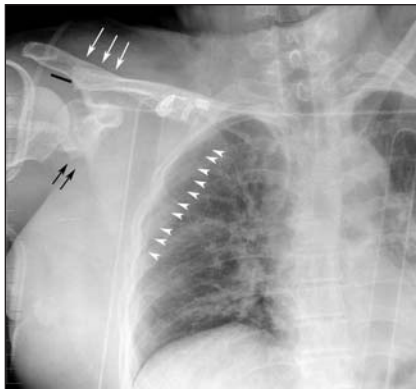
Initial chest radiograph. Further examination of the chest radiograph by the trauma team revealed the following pertinent problems: lateralization of the medial border of the scapula (small arrowheads), depression of the lateral end of the clavicle (large white arrows) and a 15-mm gapping of the acromioclavicular joint (black bar). A scapular neck fracture can also be seen (black arrows).
